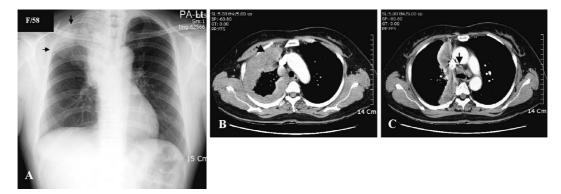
Chest X-ray revealed apical pleural thickening in the right thorax and a mediastinal contour bulging into the right suprahilar area (A). The chest CT showed diffuse irregular thickening of the right upper pleura and poorly defined mass opacity in the right upper lobe, which was inseparable from the pleural lesion (B). It also showed diffuse thickening of the right mediastinal pleura and enlarged lymph nodes in the bilateral lower paratracheal chains (C).
